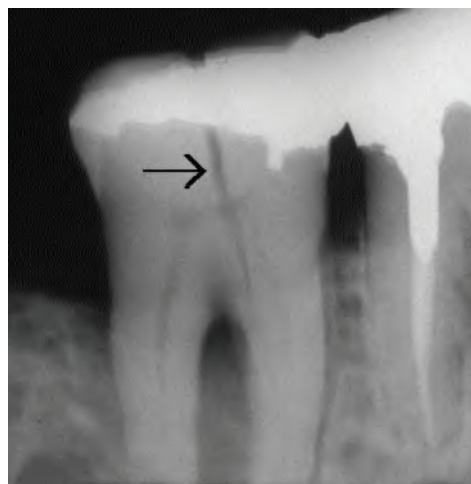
Radiograph of a mandibular molar showing a fracture (arrow) located in a bucco-lingual orientation. Because the X-ray beam runs parallel to the fracture, it becomes readily visible on the film.
